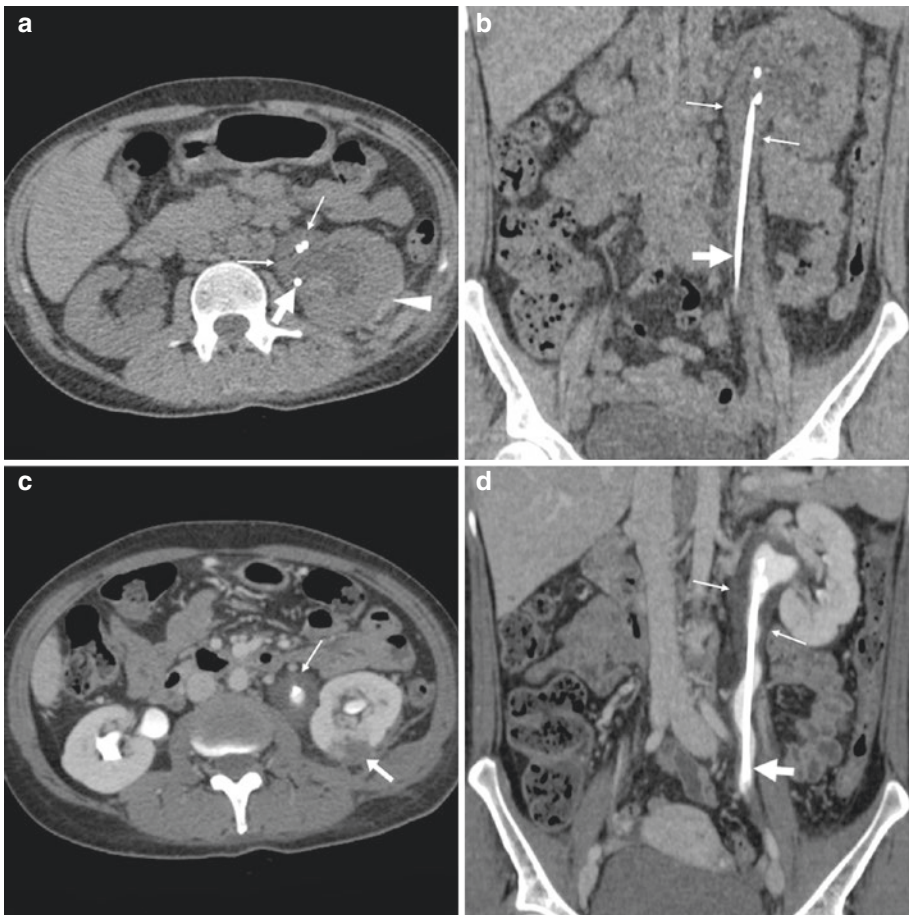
Following percutaneous nephrolithotomy (PCNL) treatment performed to treat a 2-cm left renal pelvis stone, a 46-year-old woman was not discharged because of progressive, asymptomatic haemoglobin drop (nadir 8.4 g/dL). Four days later, unenhanced CT showed ureteral stent (thick arrows) in place, hyperattenuating (50 HU) circumferential mural thickening of the renal pelvis and proximal ureter (thin arrows in a, b) consistent with suburothelial haemorrhage and minimal blood in the ipsilateral perirenal and posterior pararenal spaces (arrowhead in a). CT urography (c, d) showed functioning left kidney with a 2-cm devascularized injury (arrow in c) at the dorsal middle third and hypodense suburothelial haemorrhage (thin arrows) compared to the well-opacified pyeloureteral lumen. Conservative management including blood transfusions allowed hospital discharge in a few days, normalization of clinical, biochemistry and imaging abnormalities within a month (Reproduced from Open Access Ref. no. [22])
